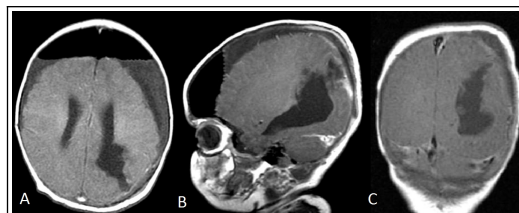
Post-operative MRI demonstrating gross total resection and the superior parietal lobule approach.
